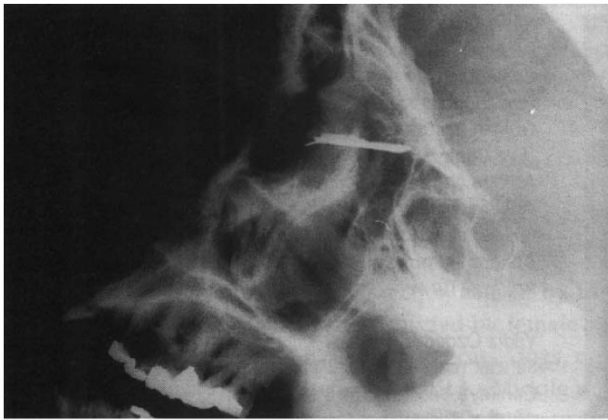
Lateral plain radiograph.
